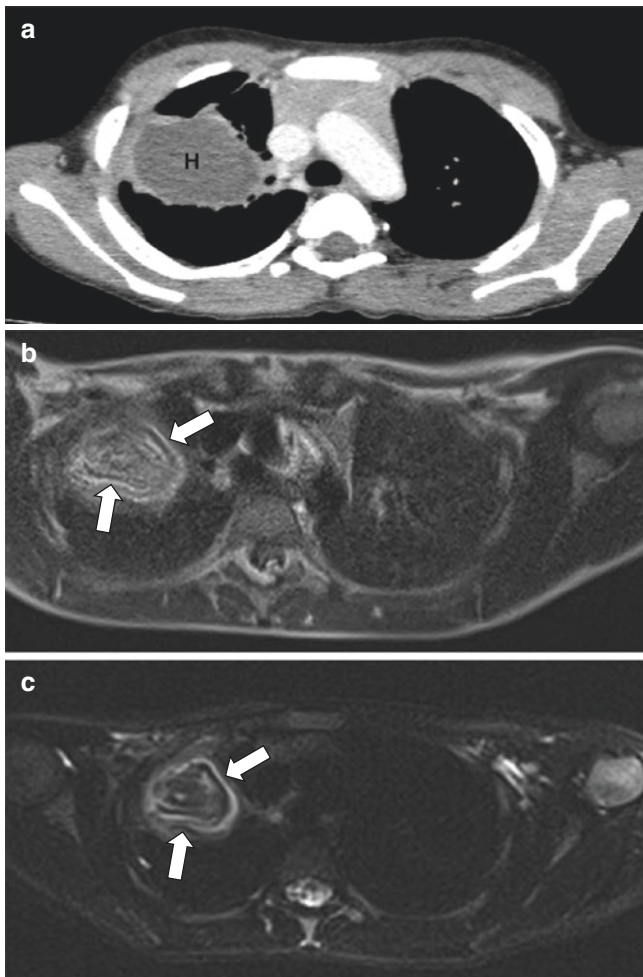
Pulmonary hydatid disease in a 10-year-old boy who presented with chest pain and cough. (Courtesy of Kushaljit Singh Sodhi, MD, PhD, Department of Radiodiagnosis, Postgraduate Institute of Medical Education and Research, Chandigarh, India). (a) Axial enhanced soft tissue window setting CT image shows cystic lesion (H) with peripheral enhancement in the right upper lobe. (b) Axial non-enhanced T2-HASTE-weighted MR image shows internal folded membranes (*arrows*) within the cystic lesion. (c) Axial non-enhanced T2-BLADE-weighted MR image shows internal folded membranes (*arrows*) within the cystic lesion
